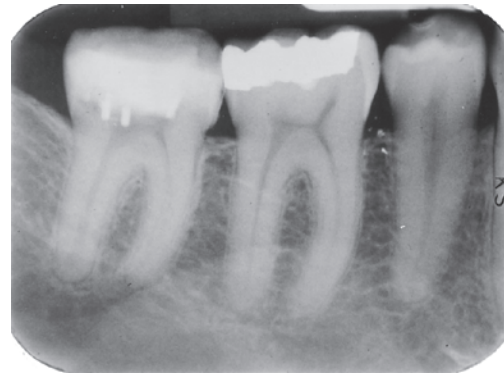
Radiographic evidence of amalgam tattoo.*
